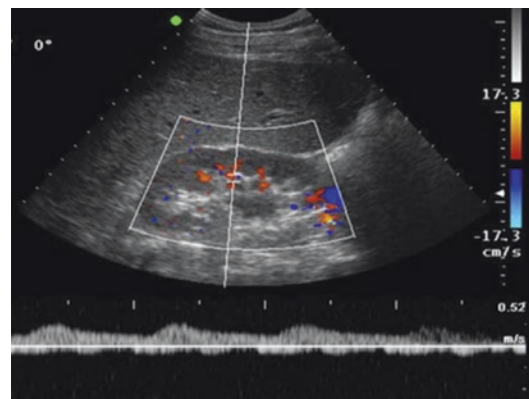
Tardus-parvus phenomenon: an indirect criterion for diagnosis of renal artery stenosis. In the presence of renal artery stenosis, intrarenal Doppler analysis may reveal a slow and late (*tardus*), little and small (*parvus*) peak systolic velocity (*PSV*) which is useful for RAS diagnosis. Slowing acceleration index, increase in acceleration time, and loss of early systolic peak (ESP) waveform enable RAS identification with 95% sensitivity and 97% specificity. Moreover, the *tardus-parvus* phenomenon predicts a successful revascularization intervention
